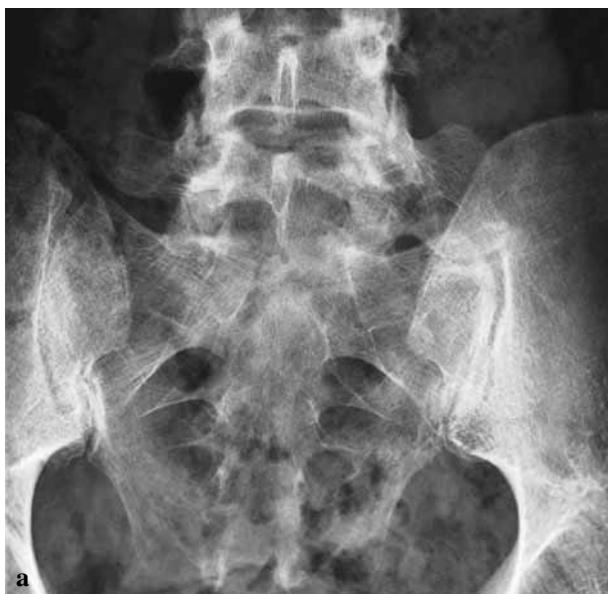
(a) Plain A-P radiograph of a patient with low back pain without radiculopathy and a unilateral (left-sided) LSTV, type IIa according to Castellvi ; (b) T1-weighted sagittal MRI scan of the same patient, showing a disc herniation, typically above the LSTV.
